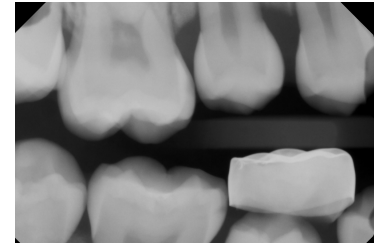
10/2016 radiograph.
